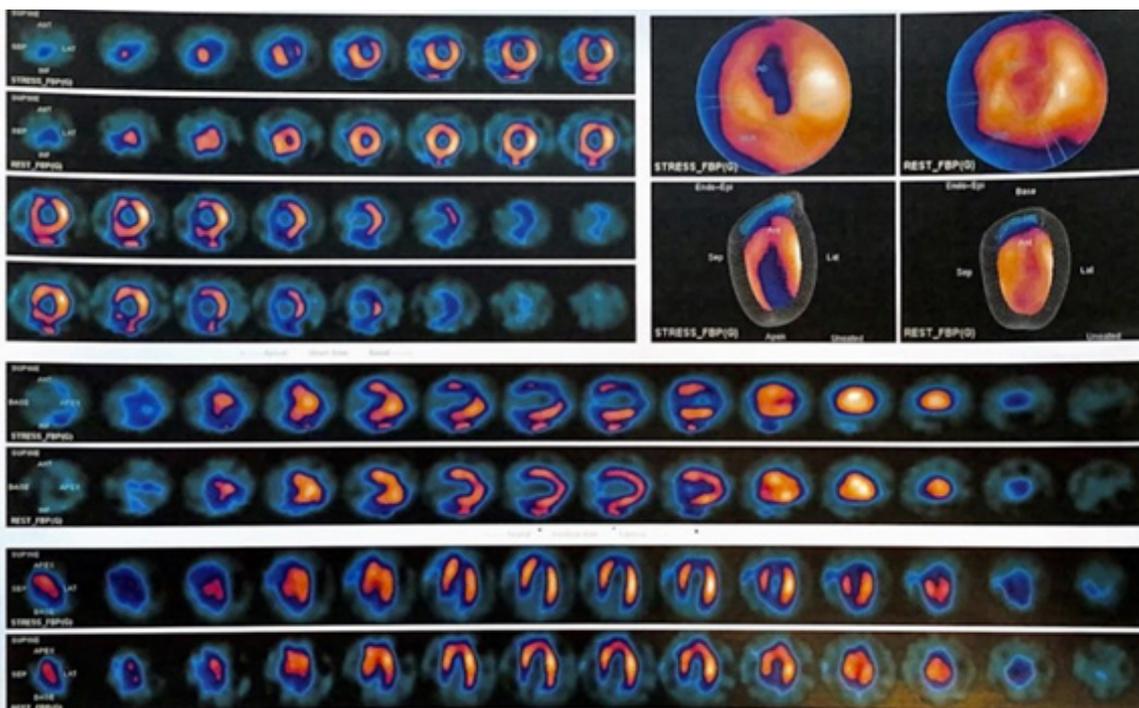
Myocardial scintigraphy was performed using Technetium Tc-99m sestamibi as the radiotracer pharmacological test. Concentration defects and perfusion abnormalities in the apical and anterior myocardial segments.
